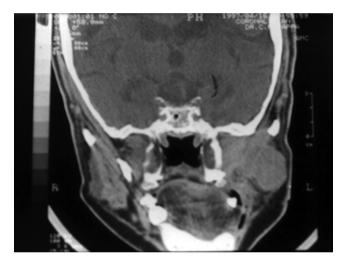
Coronal CT image–showing a lobulated well-defined soft tissue mass extending from the infratemporal fossa to involve the soft tissue of the left cheek.
